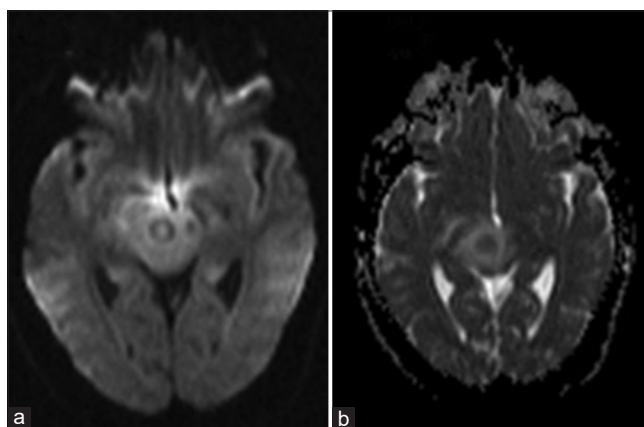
Central portion of the midbrain lesion with restricted diffusion in favor of an abscess as evident by the central high signal intensity on diffusion-weighted imaging (DWI) (a) and central low signal intensity on apparent diffusion coefficient (ADC) (b)
